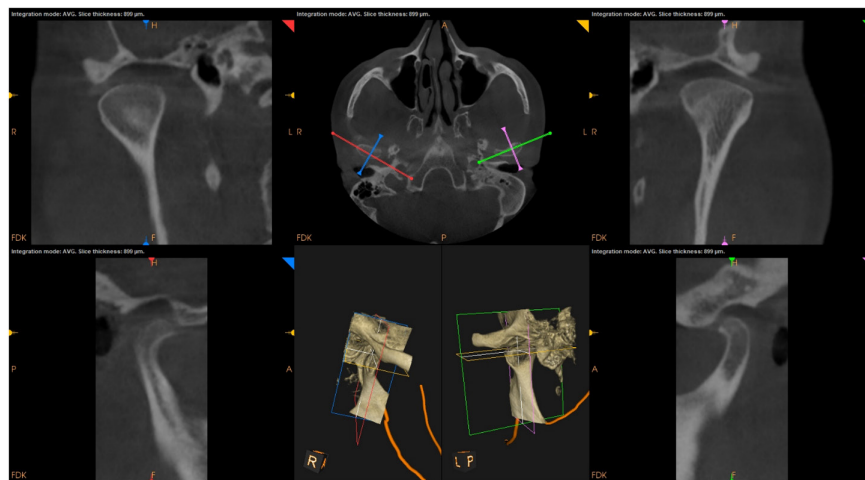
CBCT images showing coronal axial, sagittal, and 3D reconstructed views of the TM joint.
